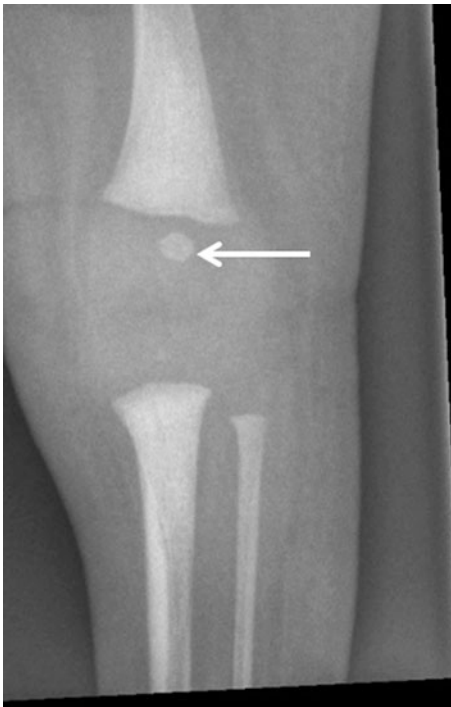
Radiograph of a 3-day-old boy showing the shaft of the femur, tibia, and fibula (primary centers of ossification developing intrauterine). The radiograph also shows the distal femur ossification center which is the only secondary ossification center present at birth (*arrow*). Proximal tibial and fibular epiphyses cannot be seen in the radiograph because they are still cartilaginous
